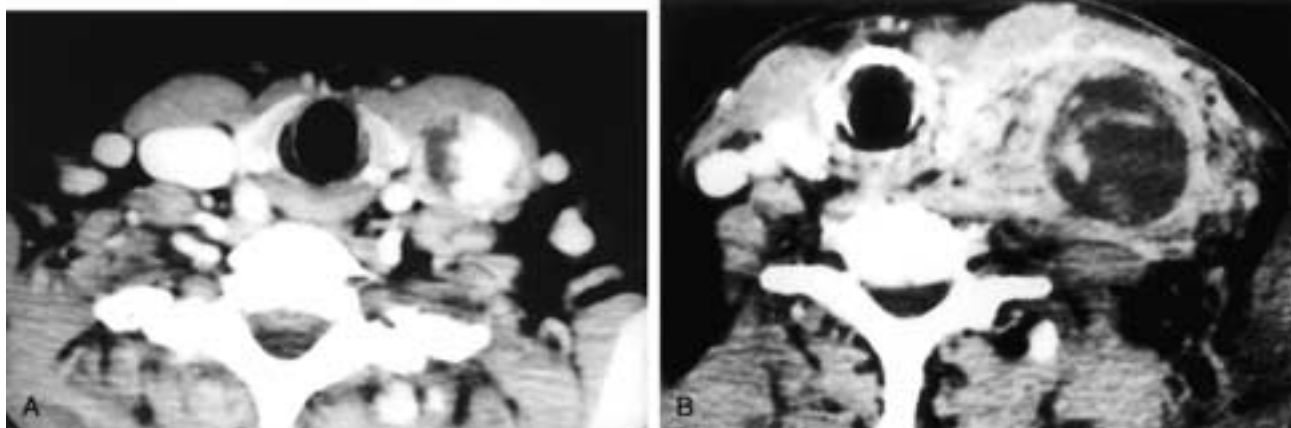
Axial contrast-enhanced CT scans. In A, there is a partially enhancing, partially cystic left level IV node. This was a metastatic papillary thyroid carcinoma node with hemorrhage. In B, there is a large, necrotic left level IV node with extracapsular tumor spread. Within the node are areas of higher attenuation that represent hemorrhage in this patient with metastatic hypernephroma.
